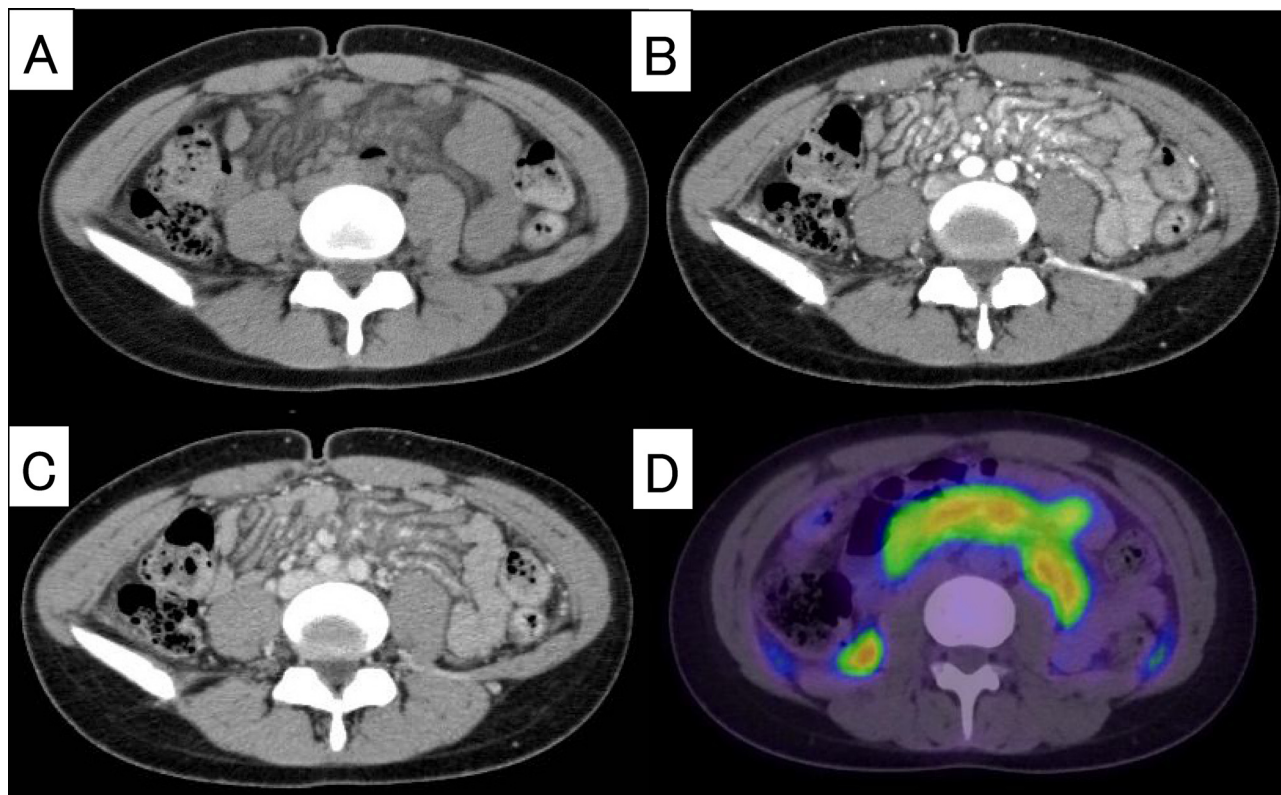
CT and FDG-PET/CT images of activated mesenteric BAT. A: Axial non-contrast-enhanced CT showed increased attenuation of the visceral fat tissues. Contrast-enhanced CT showed early enhanced (B) and delayed washed out (C) and a spaghetti-like appearance in the mesentery. Intense FDG accumulation in the mesentery was observed (D, SUVmax = 8.1).
